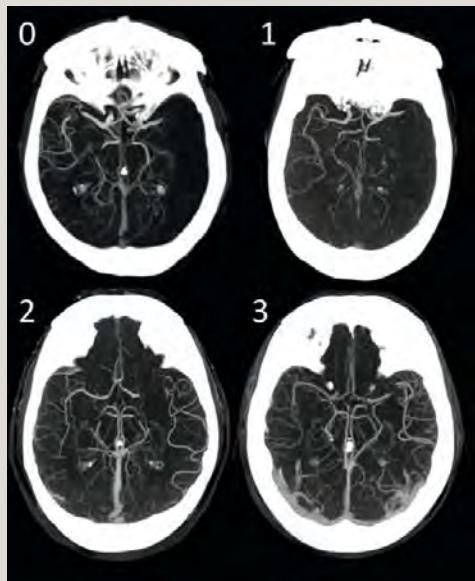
Collateral flow grades on CTA. Grade 0 = no collateral filling; grade 1 = 1-50% collateral filling; grade 2 = 51-99% collateral filling; grade 3 = 100% collateral filling. [6]
